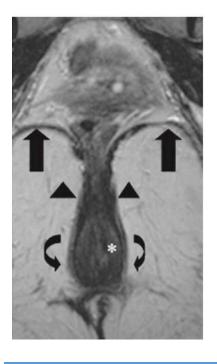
Normal anal sphincter complex. Coronal T2 weighted MR image shows the levator ani muscle as a hypointense structure (black arrows) forming the pelvic floor. The puborectalis muscle (arrowheads) is depicted at the insertion of the levator ani muscle onto the anal canal. The external (curved arrows) and internal (asterisk) anal sphincters are also seen.
